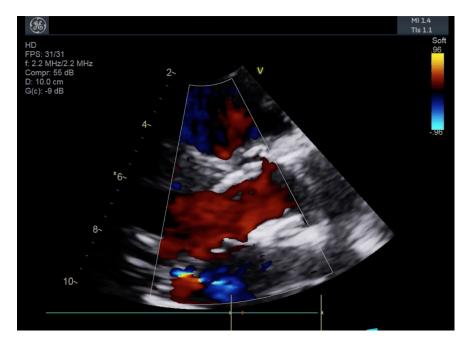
Transthoracic Echocardiogram in parasternal long axis view post balloon valvuloplasty of the prosthetic aortic valve demonstrating the resolution of valvular regurgitation.
